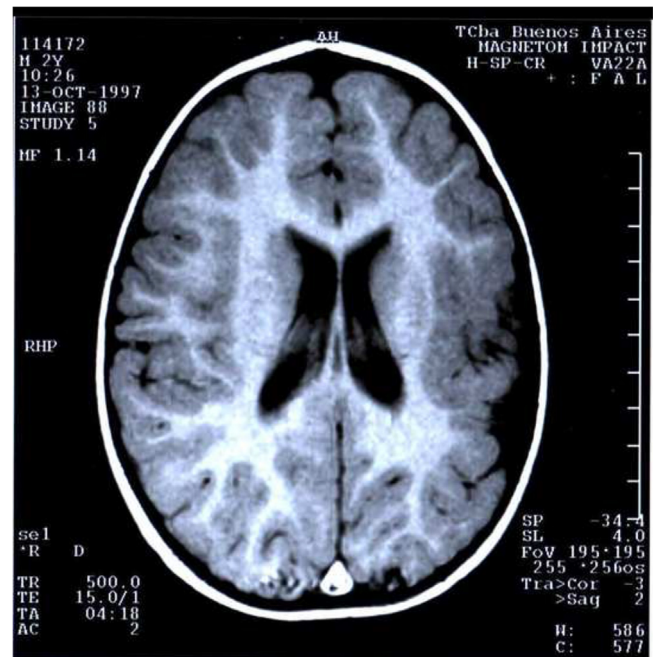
Axial T1-weighted brain MRI showing extensive left PMG with atrophy of the ipsilateral hemisphere in a 10-year-old boy.
